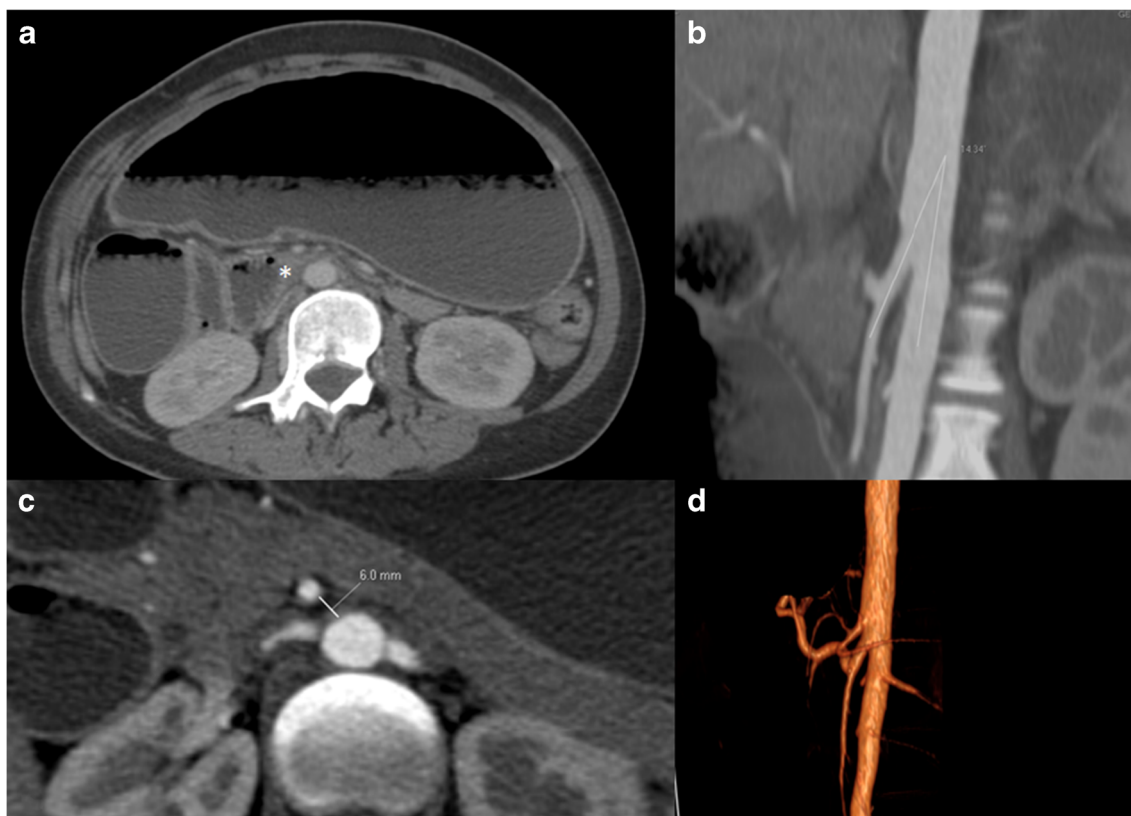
Abdominal computed tomography scan. a Axial section showing a decrease in the lumen of the third portion of the duodenum (*). b Sagittal reconstruction demonstrating decreased aortomesenteric angle
